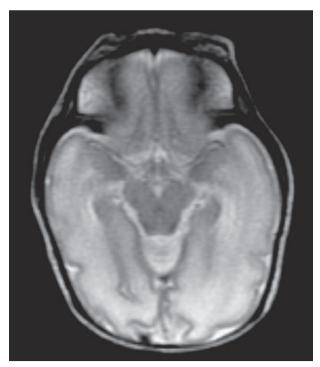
A T2-weighted magnetic resonance imaging scan of the brain of a normal baby at 31 weeks CA shows the relatively smooth appearance of the cortical surface and the rudimentary gyral pattern seen at this gestational age. The small amount of cerebrospinal fluid over the surface of the hemispheres appears white in this sequence. Prematures between 24 and 30 weeks CA have an even less developed cortical folding pattern.
